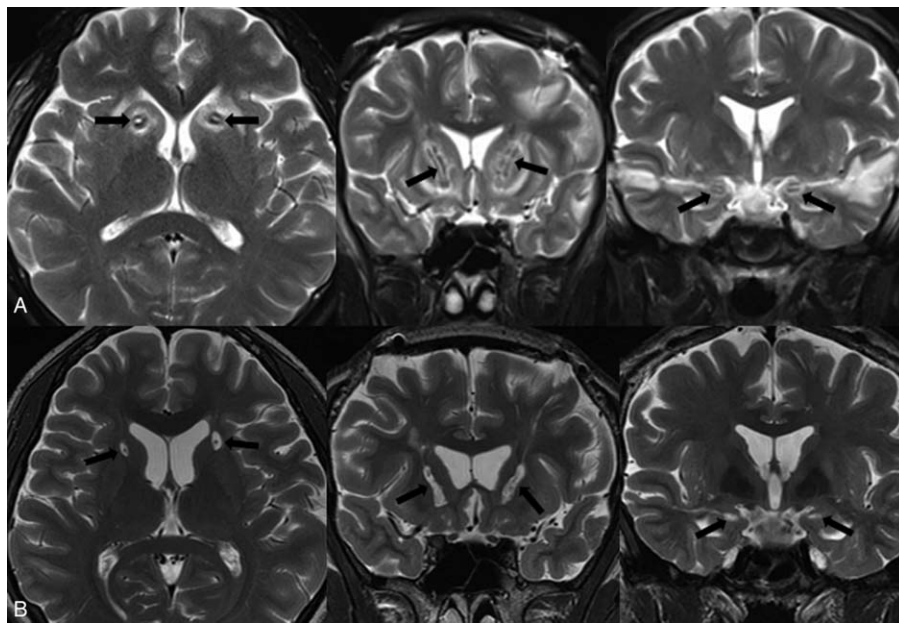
(A) T2-weighted MRI 10 days after the first surgery. (B) T2-weighted MRI 12 months after the first surgery. Black arrows indicate lesions produced by the first surgery.
